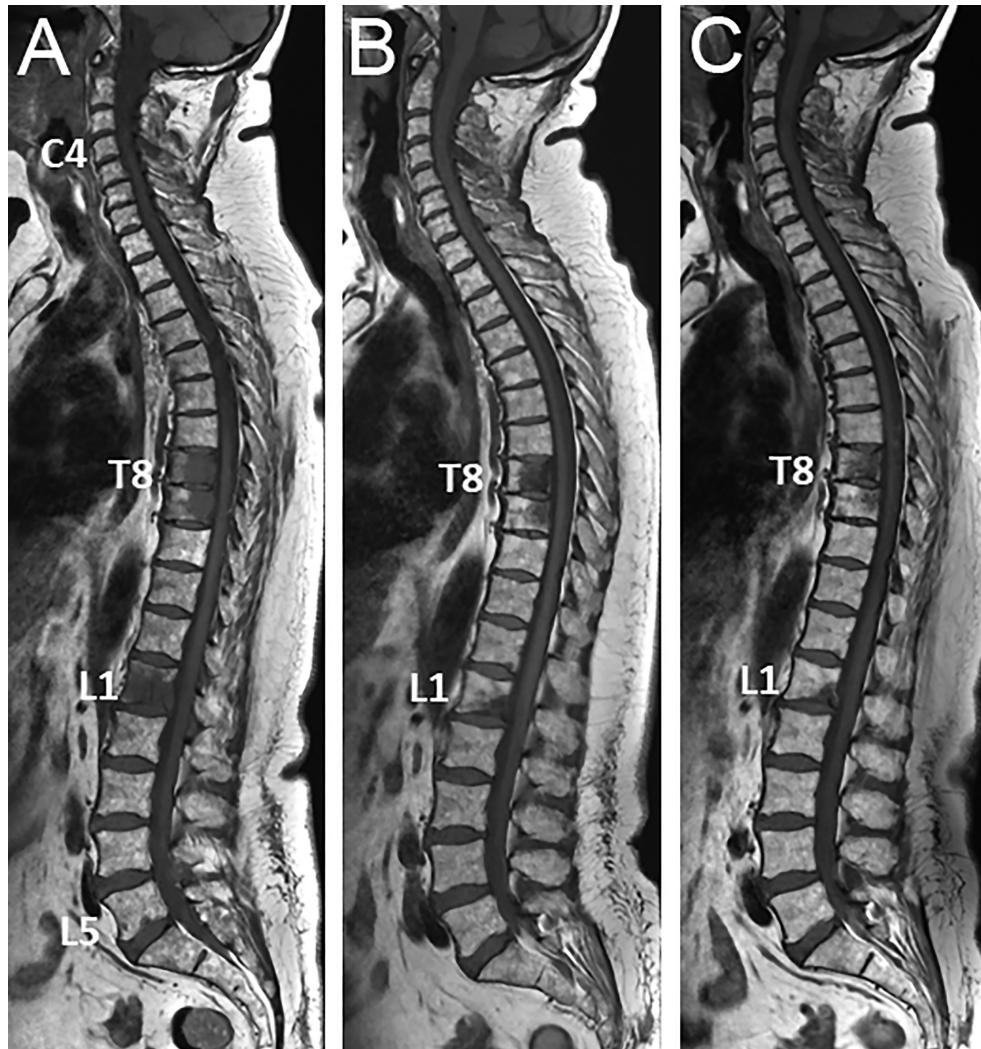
53 year-old woman with newly diagnosed metastatic breast cancer (grade II ductal carcinoma, ER 8, PR8, KI 67 5%, HER2 neu 2+): spinal MRI findings at diagnosis of bone metastases and during treatment. (A) Baseline sagittal T1-weighted MR image of the whole spine shows multiple foci of low signal intensity of the bone marrow, typical for bone metastases (posterior arch of C4, vertebral bodies of T8, T9, L1, tiny foci in L5). (B) Corresponding MR image obtained 2-m later after combined treatment including a selective estrogen receptor degrader (SERD) and palbociclib shows significant decrease in size of all lesions, and disappearance of the small L5 foci. (C) Follow-up MR image obtained 2-m later shows further decrease in size of all lesions, with measurable decrease in lesion size and reappearance of fatty marrow at the periphery and within the lesions, again indicating frank response to treatment.
